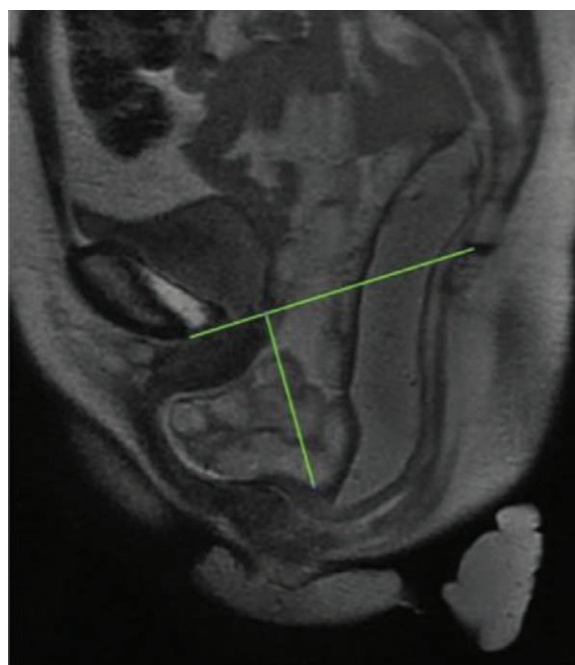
Pubococcygeal line, extending from the most inferior portion of the pubis symphysis to the last horizontal coccygeal joint. Descent of any particular structure is measured along a perpendicular line from the pubococcygeal line to the structure. This case shows a large enterocoele (grade 3). Reprinted with permission from Magnetic Resonance Imaging Clinics of North America 2013;21:427–445.
